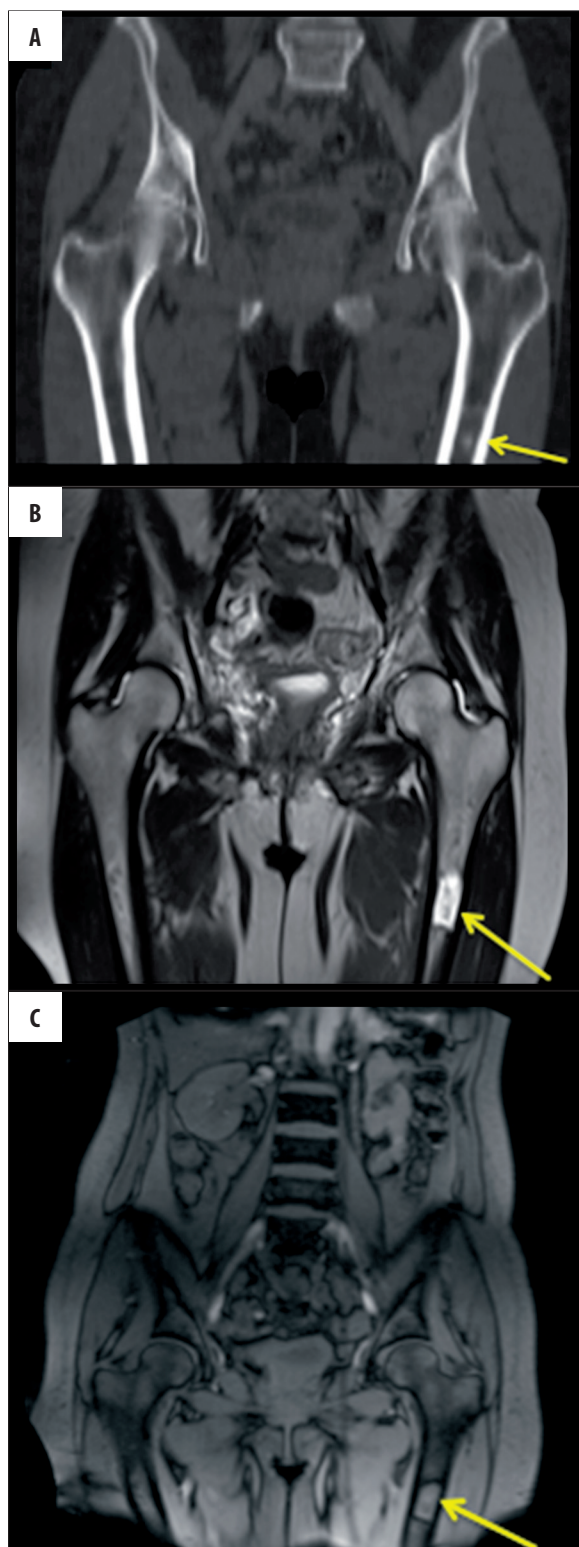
(A) Coronal CT image in which a focal structural alteration in the third proximal of the left femur is evident. (B) Coronal TSE T2 image in which an area of hyperintensity (3.2 cm) in the third proximal of the left femur is detected as in the coronal localizer (C).
